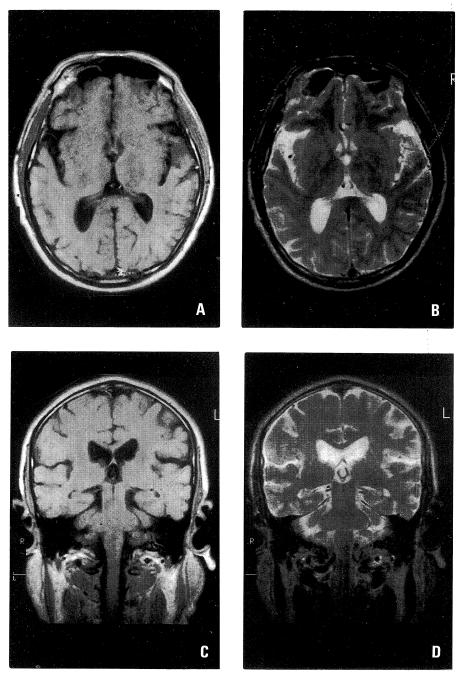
Magnetic resonance images revealing multiple small infarctions.
